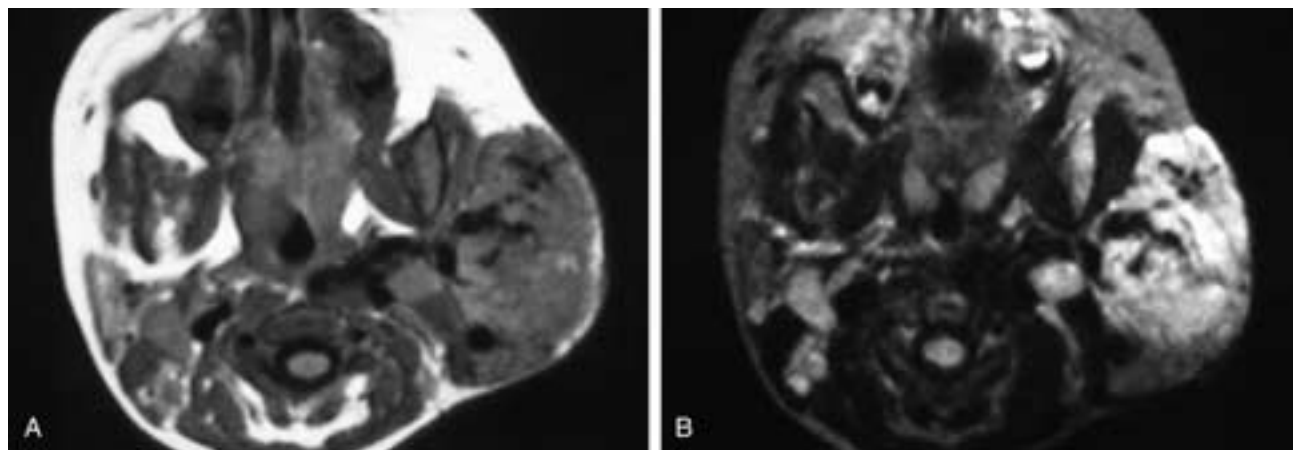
Axial T1-weighted (A) and T2-weighted (B) MR images show a soft-tissue mass in the left parotid gland. The lesion has a low T1-weighted and a high T2-weighted signal intensity, and there are large vascular flow voids within the lesion. This patient had a hemangioma.
